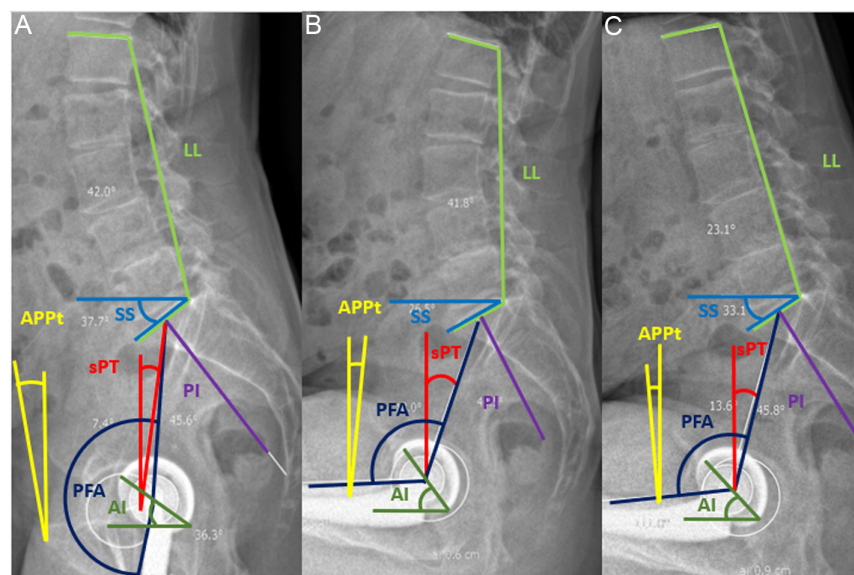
Measurements for radiographic spinopelvic parameters in the (A) standing, (B) upright seated, and (C) deep-flexed-seated position for pathological spinopelvic mobility in a hip osteoarthritis patient 1-year post-THA.
